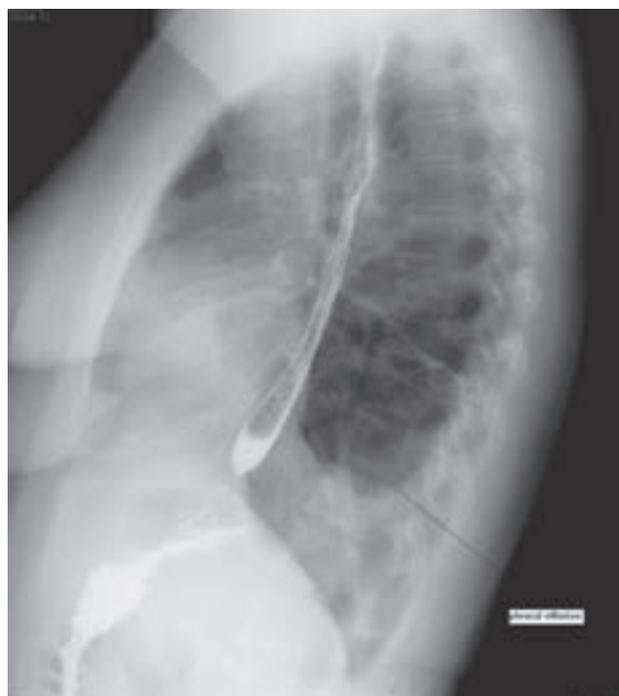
(a) posteroanterior view, (b) lateral view. With standard upright radiographs, pleural effusions are typically found originating below the lung, and create a meniscus that blunts the costophrenic angle and then tapers off superiorly.
